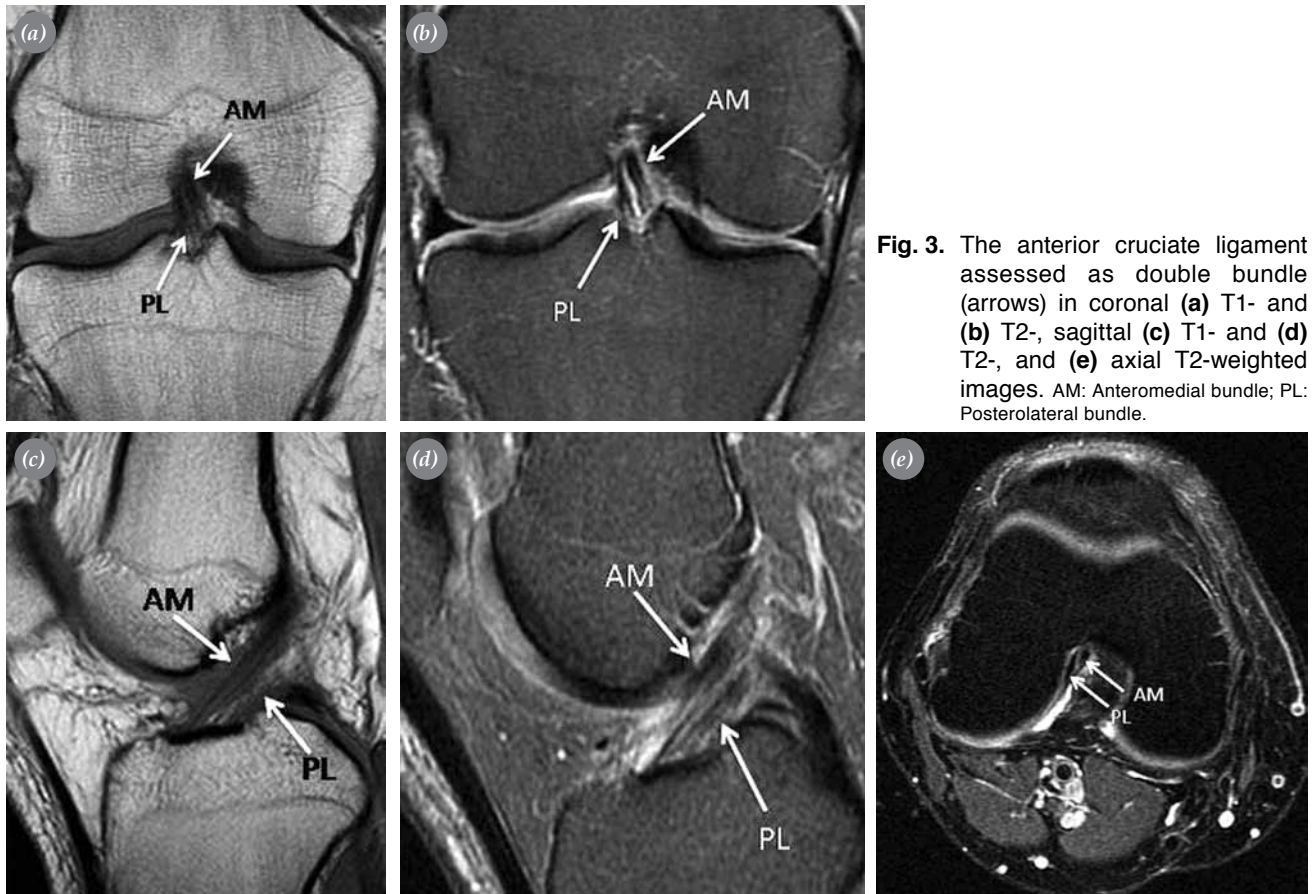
The anterior cruciate ligament assessed as double bundle (arrows) in coronal (a) T1- and (b) T2-, sagittal (c) T1- and (d) T2-, and (e) axial T2-weighted images. AM: Anteromedial bundle; PL: Posterolateral bundle.
